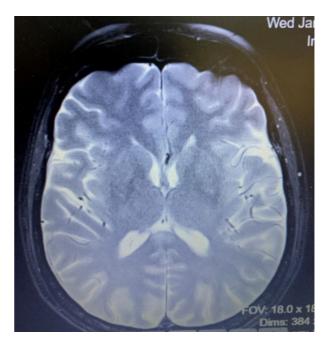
MRI brain showing multiple focal T2 FLAIR high signal intensities in the bilateral occipital lobes, parietal lobes and frontal lobes
